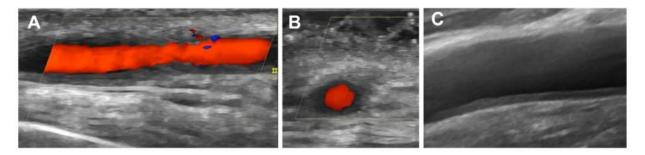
color Doppler ultrasound with a "halo sign". A: longitudinal plane of the temporal parietal artery; B: transverse plane of the temporal artery branch; C: longitudinal plane of the axillary artery. Prieto-Peña et al. (2021) ⁽³³⁾.
